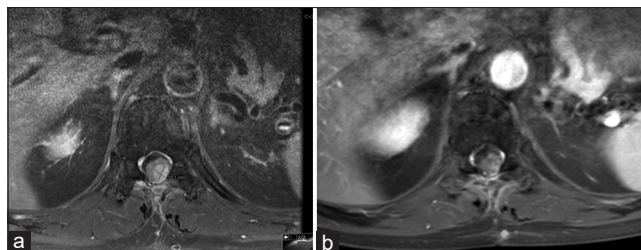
Glioblastoma multiforme at T11-12 seen on T1-weighted axial magnetic resonance image with gadolinium contrast before (a) and 1 month after (b) pulsed reduced dose-rate radiotherapy.
